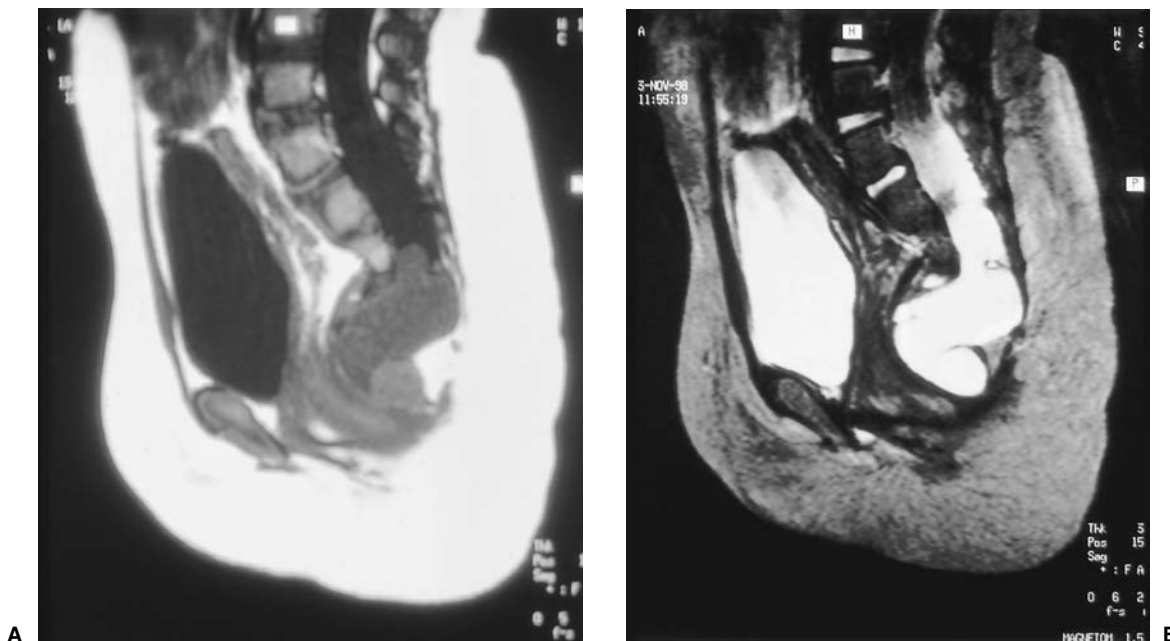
A T1-weighted image (A) showing the lower end of the thecal sac which contains CSF. Just beneath this is a large dermoid which becomes bright on the T2-weighted image (B) as does the CSF. This infant was born with an imperforate anus and required a diverting colostomy. Because of the known association between rectal anomalies and closed NTD, an MRI study was obtained. This showed the presence of this anterior sacral
